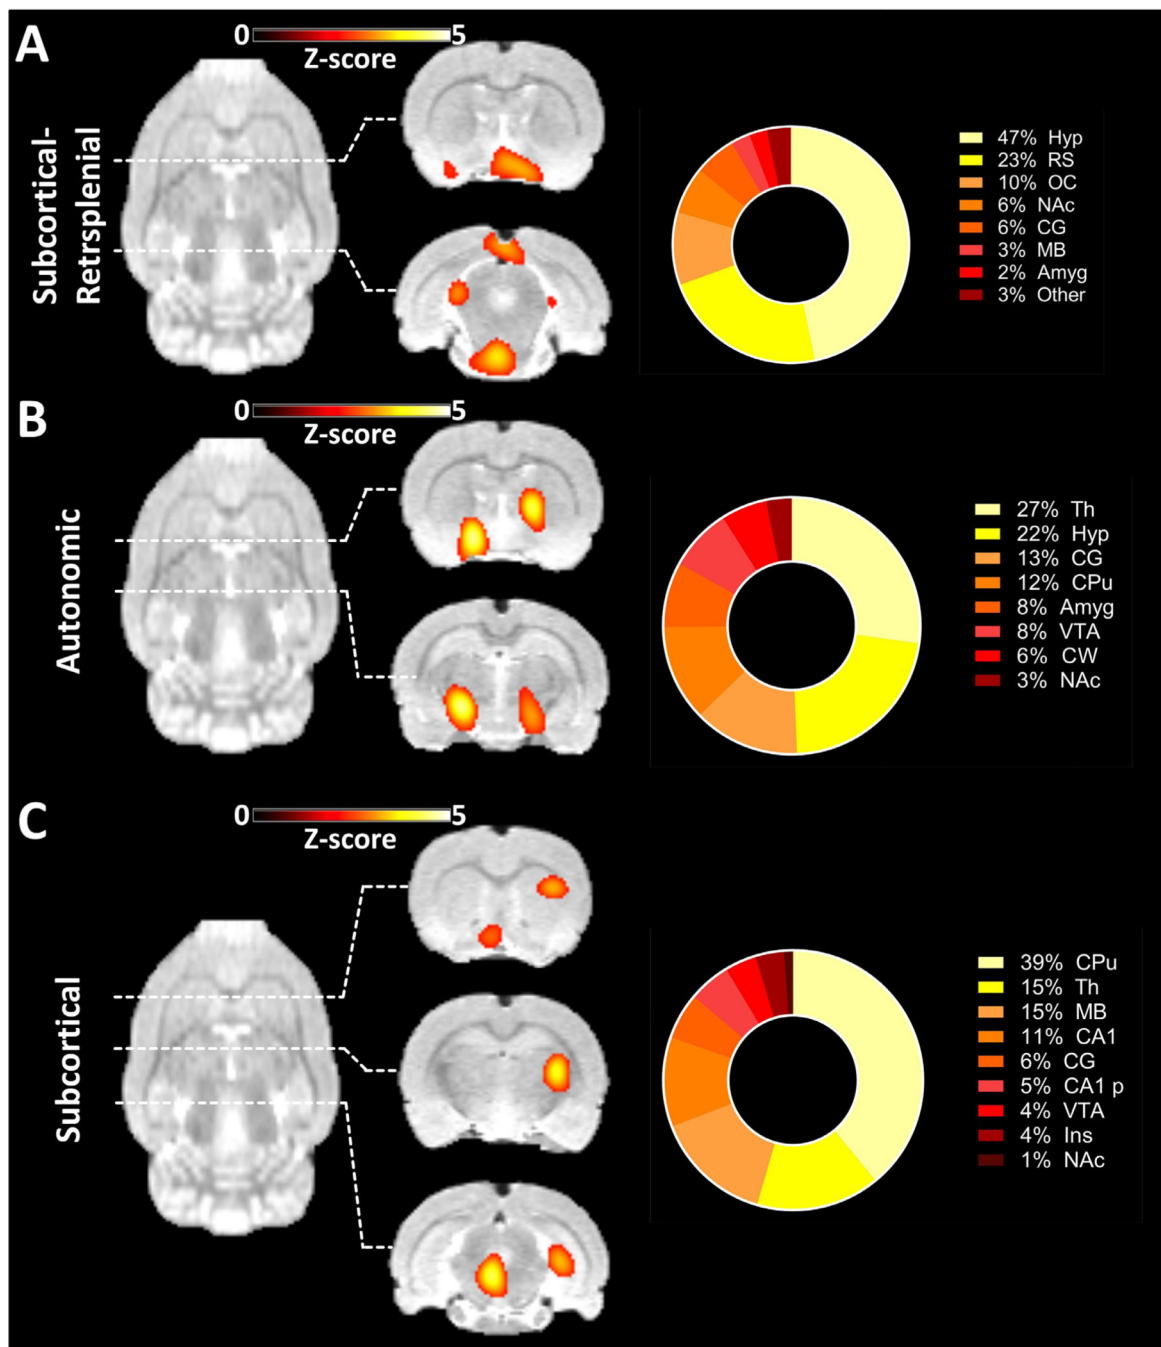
Components found exclusively in $[^{18}\text{F}]\text{FDG}$ -PET-derived ICA. (A) Component comprising the Hyp, RS, OC and other subcortical and posterior areas along with the regional quantification of the derived signal. (B) Component mainly composed of Th, Hyp and other subcortical areas along with the regional quantification of the derived signal. (C) Component comprising multiple subcortical areas along with the regional quantification of the derived
